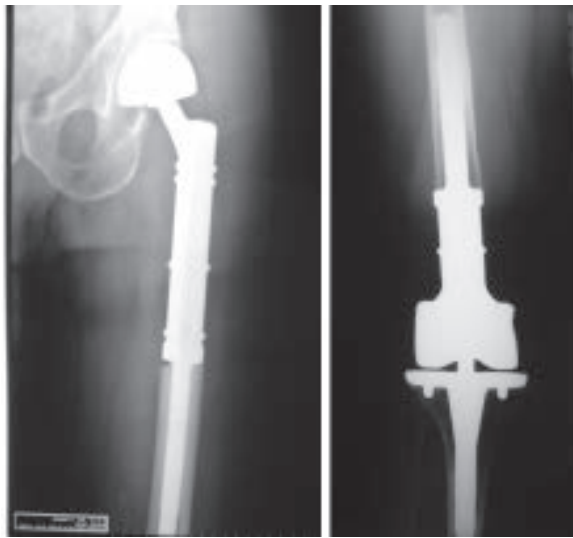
Post-operative Xray after proximal and distal femur resection and reconstruction with silver coated modular prosthesis (MUTARS® Implantcast Ltd, Buxtehude, Germany).
